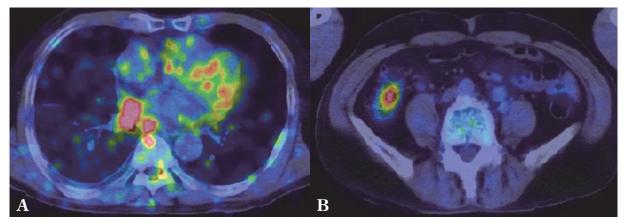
A) Positron emission tomography-computed tomography demonstrating increased ¹⁸F-fluorodeoxyglucose uptake in the right lung and B) focally increased uptake in the ascending colon.
